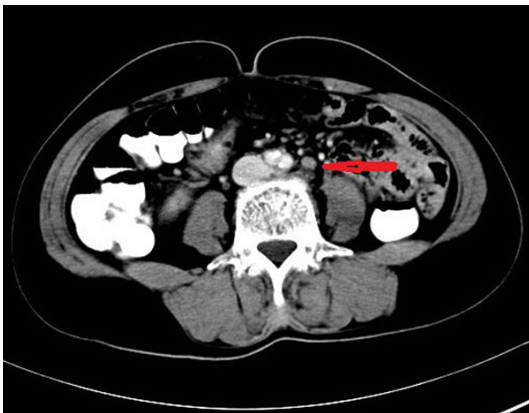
CT test for a patient with cervical cancer in stage IB2. The red arrow is pointing to a para-aortic lymph node.
